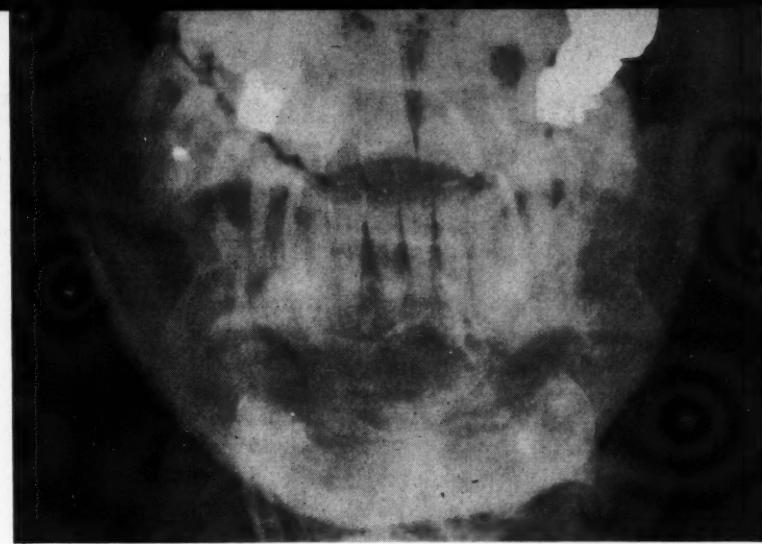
Case II: Roentgenogram three months after penicillin treatment shows bone production and fracture areas healed.
